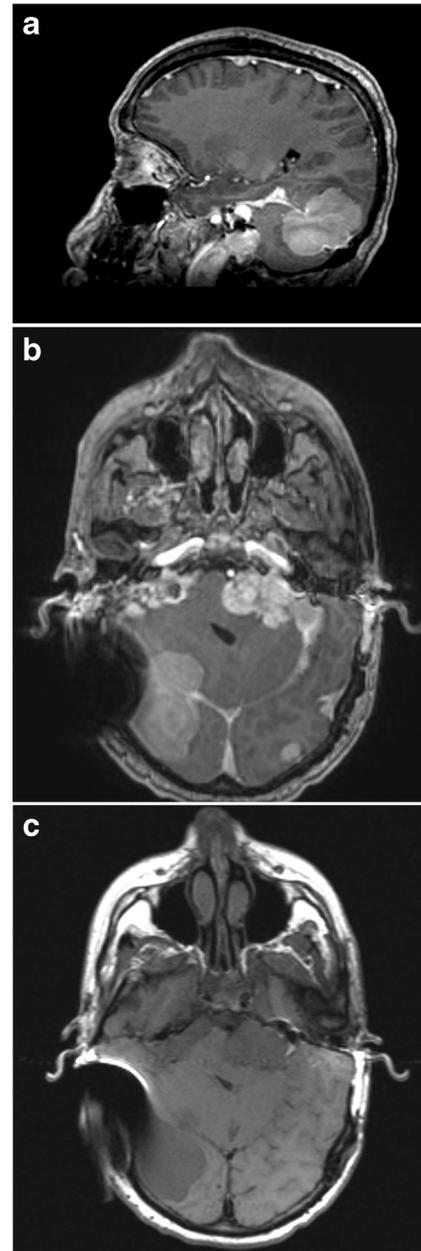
Pre-operative images for our patient. a Sagittal T1-weighted MRI with contrast; b axial T1-weighted MRI with contrast; and c axial T1-weighted MRI without contrast showing multiple meningiomas. Patient's bilateral cochlear implants contribute to artifact and image degradation
